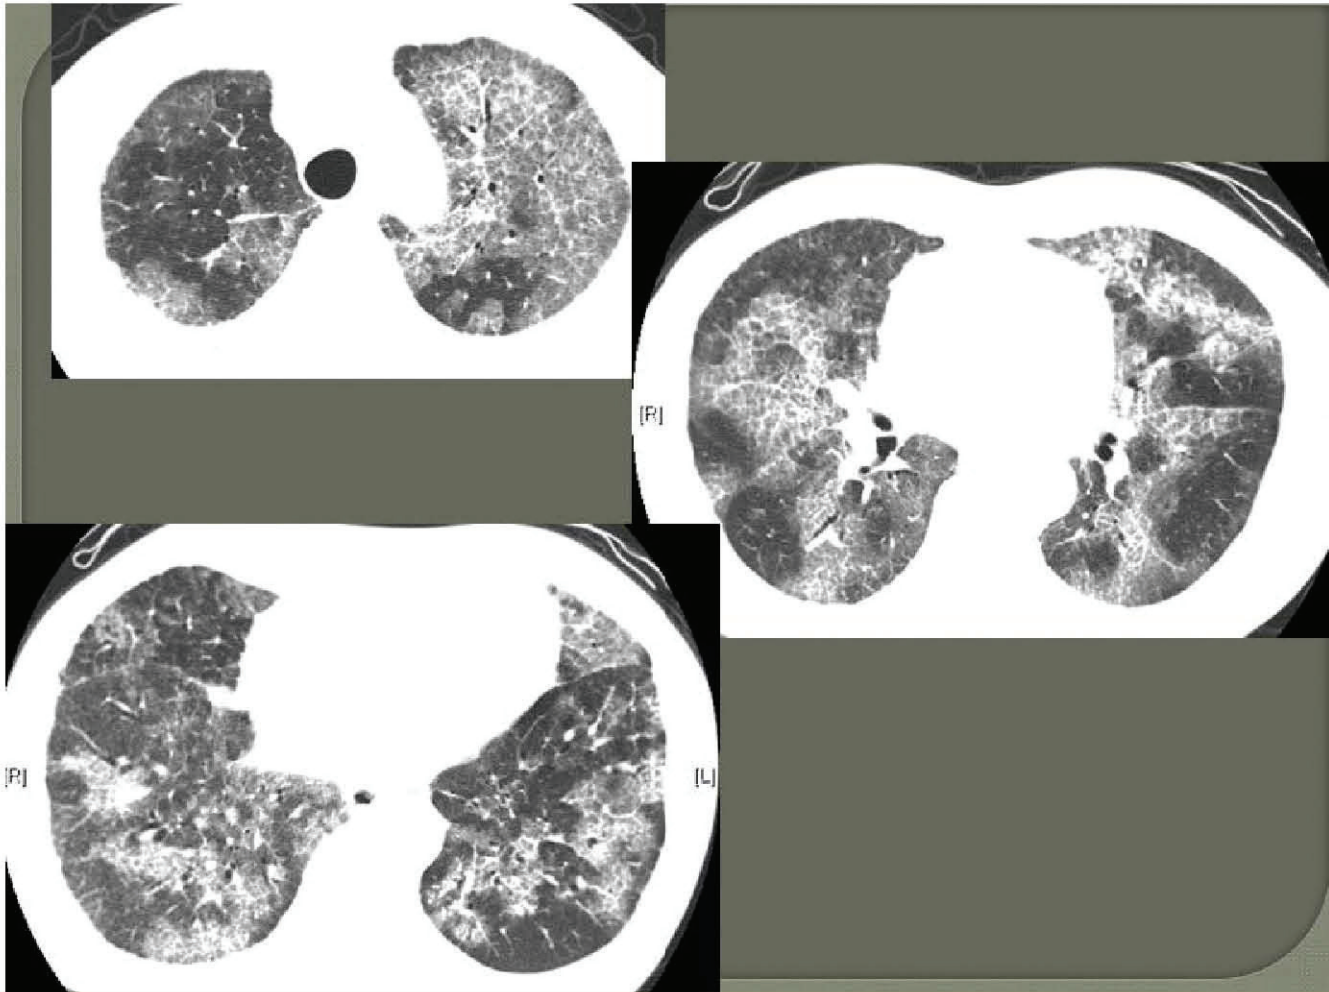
HRCT progressed after 2 months of systemic steroid
